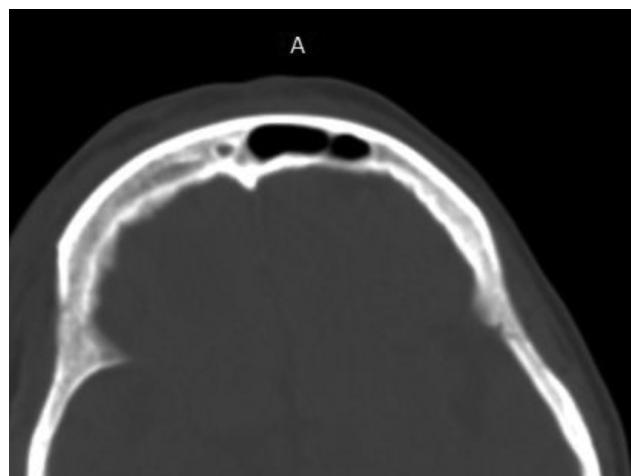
Frontal Sinus as observed in Axial section CBCT
